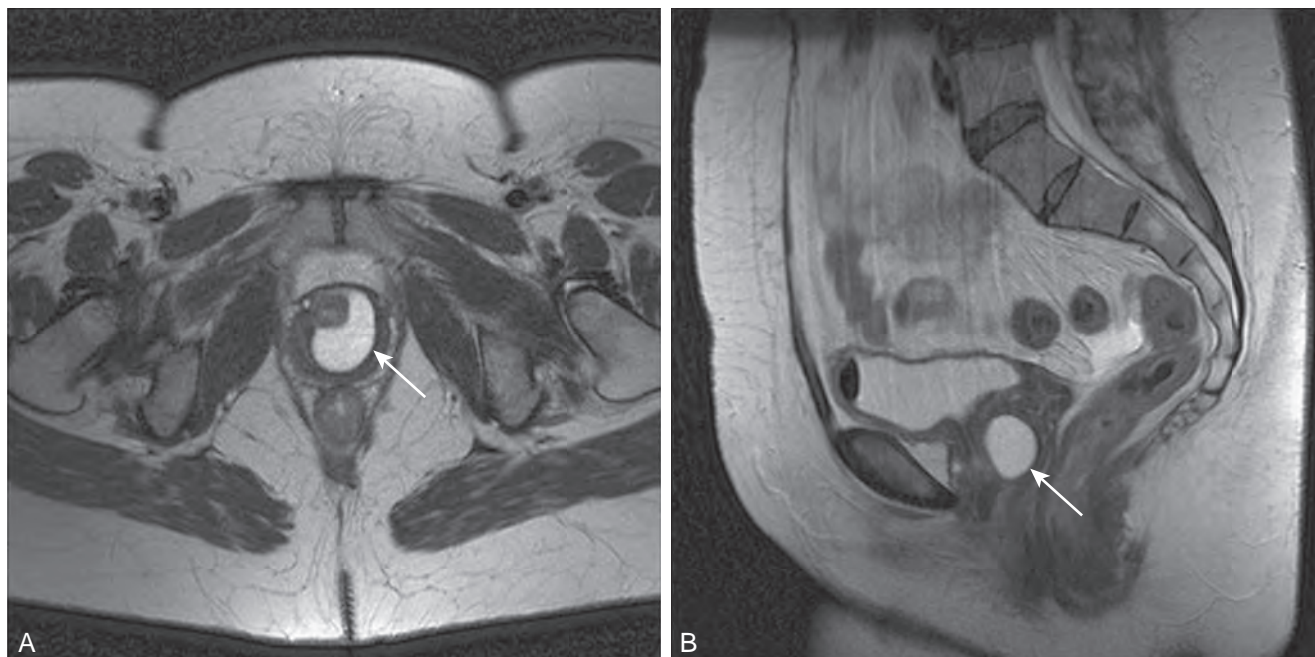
Surface coil T2 magnetic resonance image demonstrating a urethral diverticulum (arrows) in the sagittal (A) and axial (B) planes.
